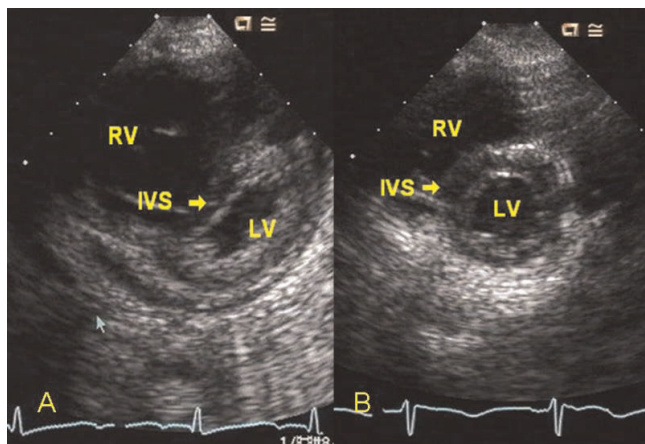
Parasternal short axis 2D echocardiographic images. (A) At the time of admission there was severe right ventricular (RV) dilation and evidence of RV hypertension with marked interventricular septal (IVS) flattening in systole. (B) At 2.5 month follow-up, the RV size is normal and there is resolution of RV hypertension with no IVS flattening in systole.
